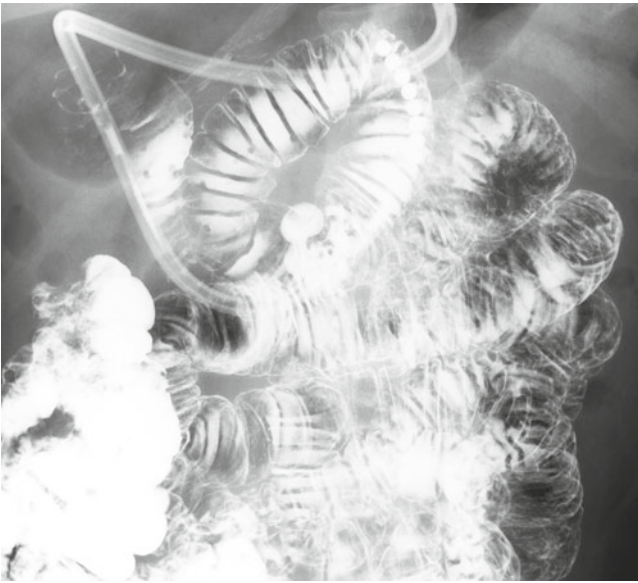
The multiple small, well-demarcated filling defects visible in this radiographic image, mainly in the jejunum, can be interpreted as a sign of multiple lesions.
